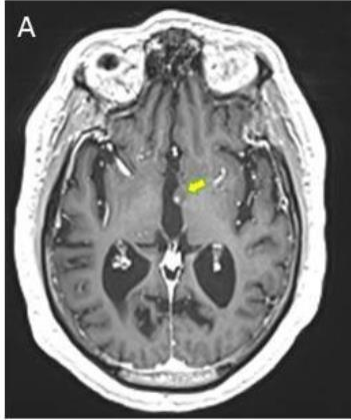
MRI of the hamartoma. (A) Sagittal T₁ image shows its connection at the third ventricle. (B) Coronal FLAIR image shows that the hamartoma has more hyperintense signal, and shows greater attachment to one side.
